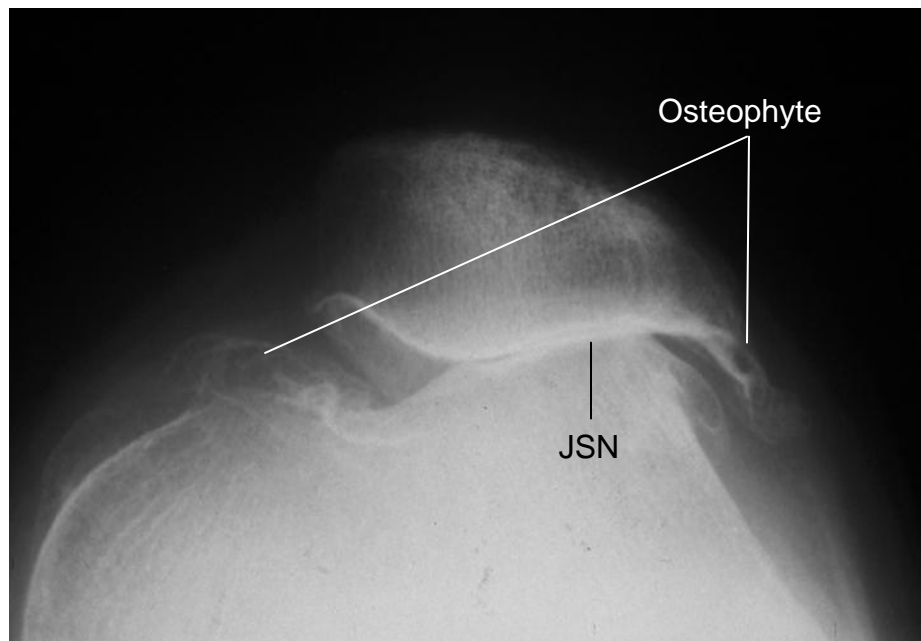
Patello-femoral radiograph showing osteophytes, JSN and lateral subluxation
